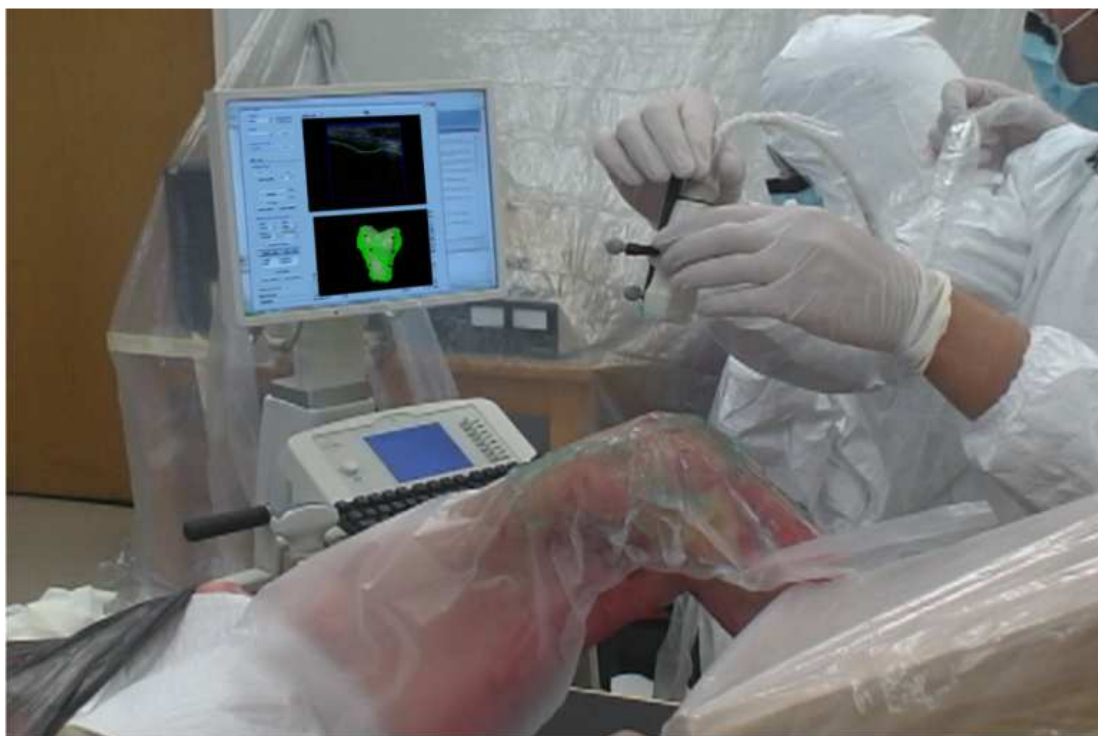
A picture for the one of the cadaveric experiments showing the developed imaging system running on the SonixRP ultrasound machine
